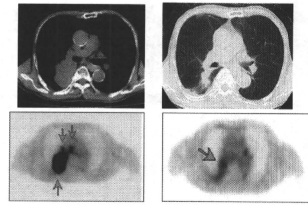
76歳、男性。非小細胞肺がん、T3N2M0 (Stage IIb)の症例。左上: 治療前CT、左下: 治療前FDG-PET、右上: 治療後6ヵ月時点のCT、左下: 治療後6ヵ月時点のFDG-PET。治療後6ヵ月の時点ではCTではPRの診断であるが、FDG-PETではbiological CRと診断され、治療後経過5年でもCRを維持している。
